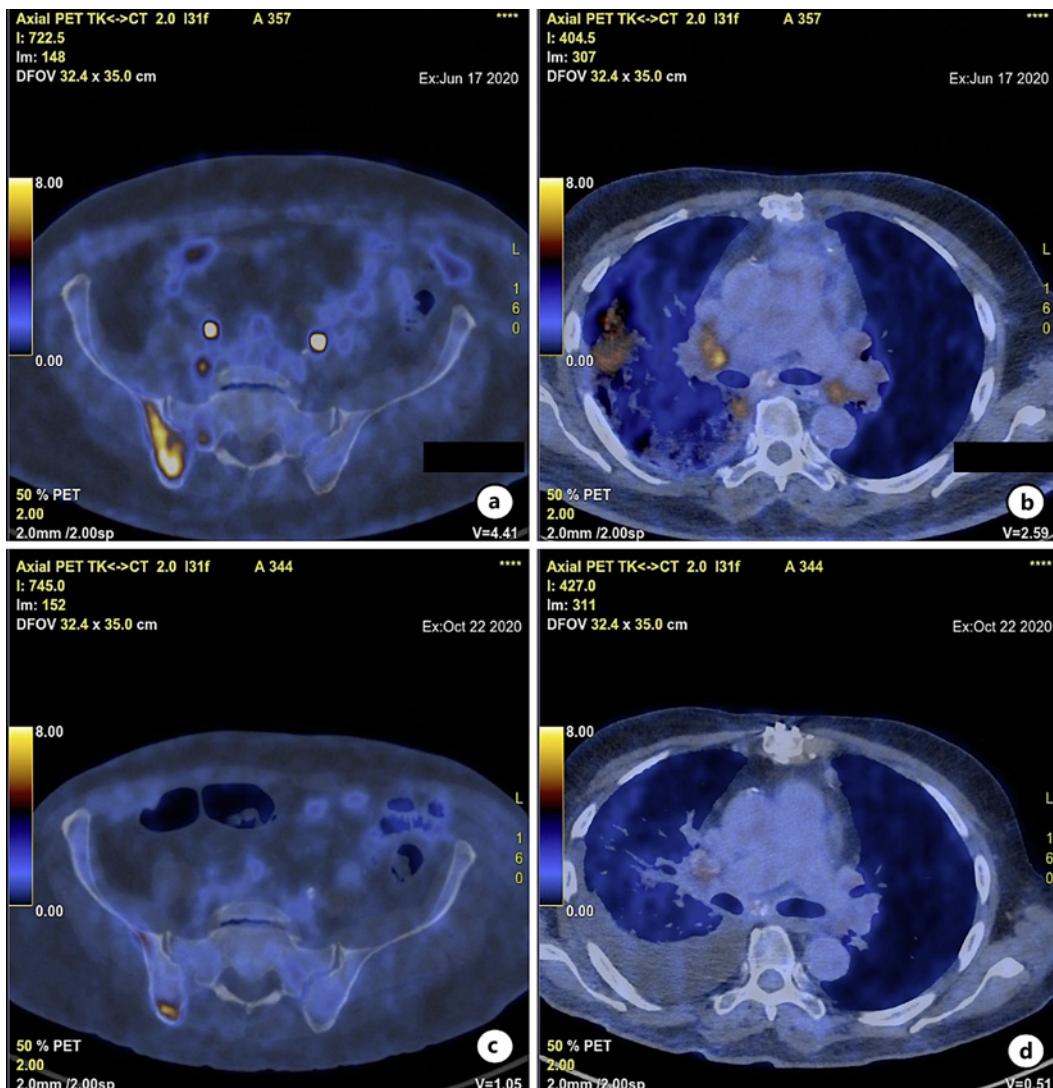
a CT scan of the pelvic region showing a clearly in size progressive intraosseous metastasis in the right posterior superior iliac spine before T-DM1 treatment. b CT scan of the lung showing several metastases in the right and left lung. c CT scan of the pelvic region 2 months after the initiation of T-DM1 treatment. d CT scan of the lung 2 months after the initiation of T-DM1 treatment, demonstrating a robust partial remission. There is a moderate pleural infusion and atelectasis visible in the right lung.
